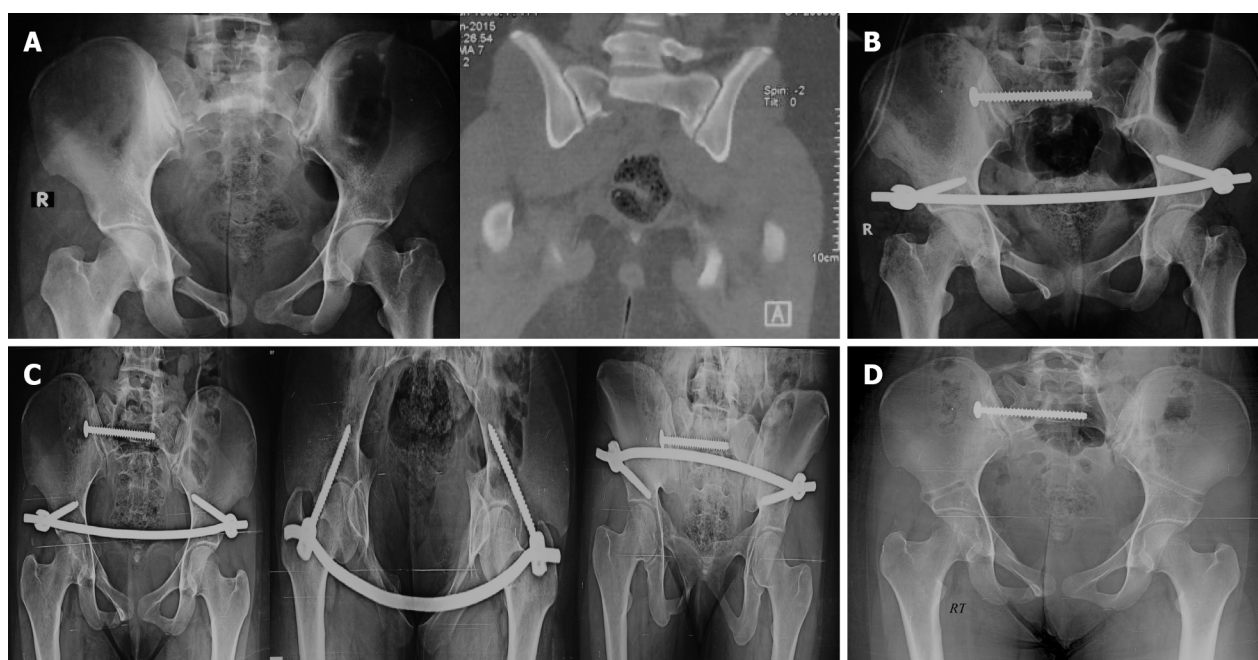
17-year-old girl sustained a Tile C type pelvic fracture after fall from a height of 6 m. A: Pelvis antero-posterior (AP) X-ray view and sagittal computed tomography scans showing sacral and ramus fractures on the Rt. Side; B: The pelvic fracture was fixed using a fully threaded sacroiliac screw and an internal fixator (INFIX); C: 3-mo follow-up pelvic X-ray (AP, inlet and outlet) views showing complete union. The INFIX was removed 2 mo later in the OR; D: One-year follow-up X-ray. The patient had excellent function with complete return to her prefracture activity level.
